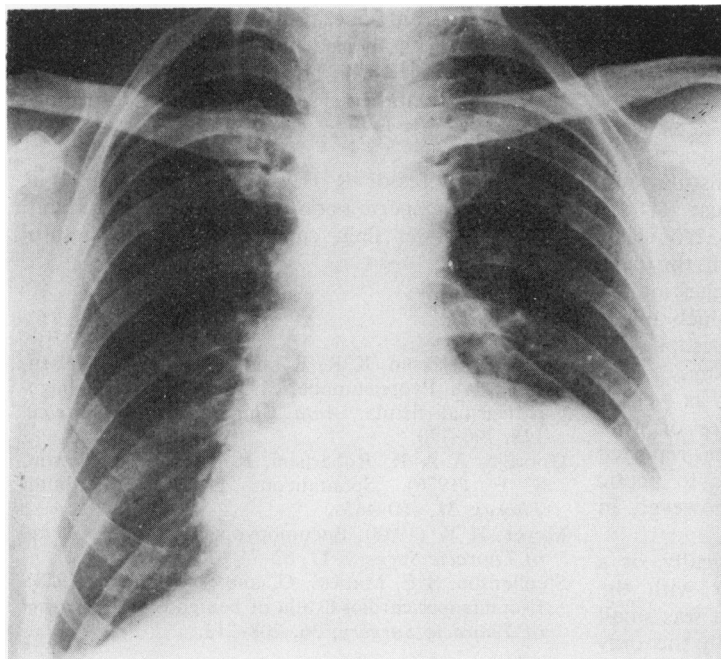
Chest radiograph taken three days after admission. Hydropneumopericardium is now more obvious.*
